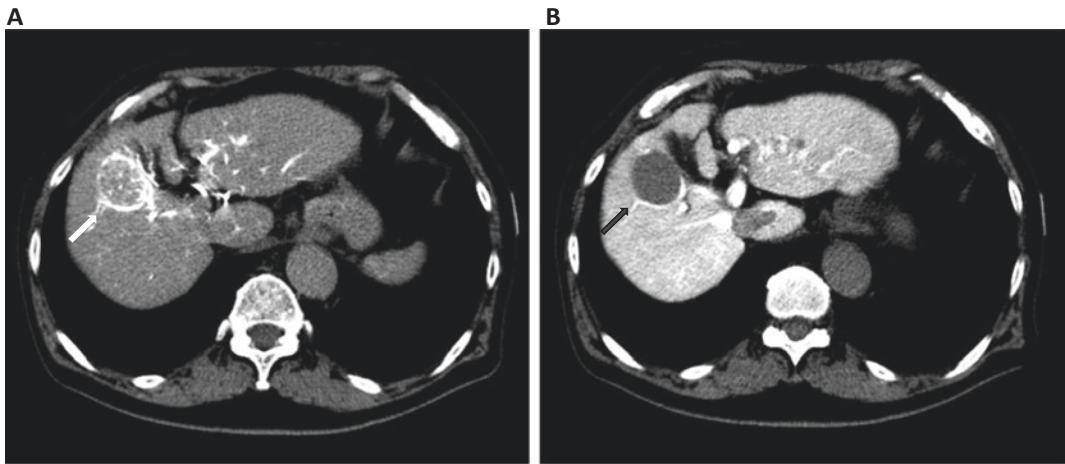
CT during arteriography/CT during arterial portography (CTA/CTAP). CTA showing hypervascular nodule (white arrow) (a) and CTAP showing hypovascular nodule (black arrow) in contact with the gallbladder (b)
